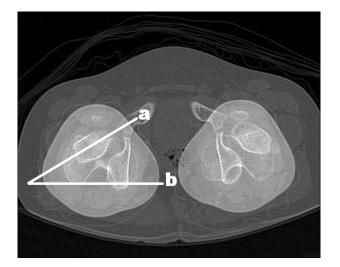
Computed tomography of right femur, which measures the angle between the line bisecting femoral head (a) and the tangent line passing posterior cortex of medial and lateral femoral condyle (b).
